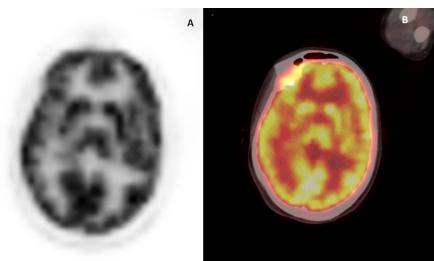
Initial 18-FDG PET scan (PET alone on the left and PET/CT fusion image centered on the brain in axial slice on the right) showing normal uptake of the glucose analogue on the cerebral cortex and basal ganglia.
